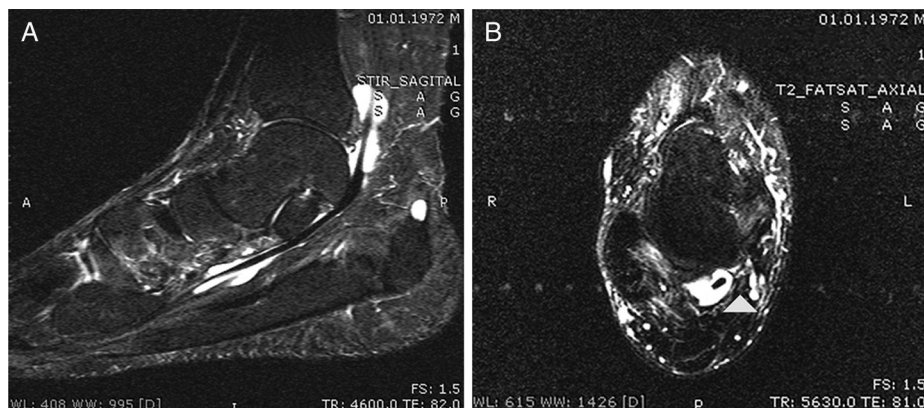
(A) T₂-weighted, fat-saturated, sagittal magnetic resonance image showing tenosynovitis of the flexor digitorum longus tendon within the tarsal tunnel. (B) T₂-weighted, fat-saturated, axial magnetic resonance image showing tenosynovitis of the flexor digitorum longus tendon within the tarsal tunnel compressing the tibialis posterior nerve (*arrowhead*).
